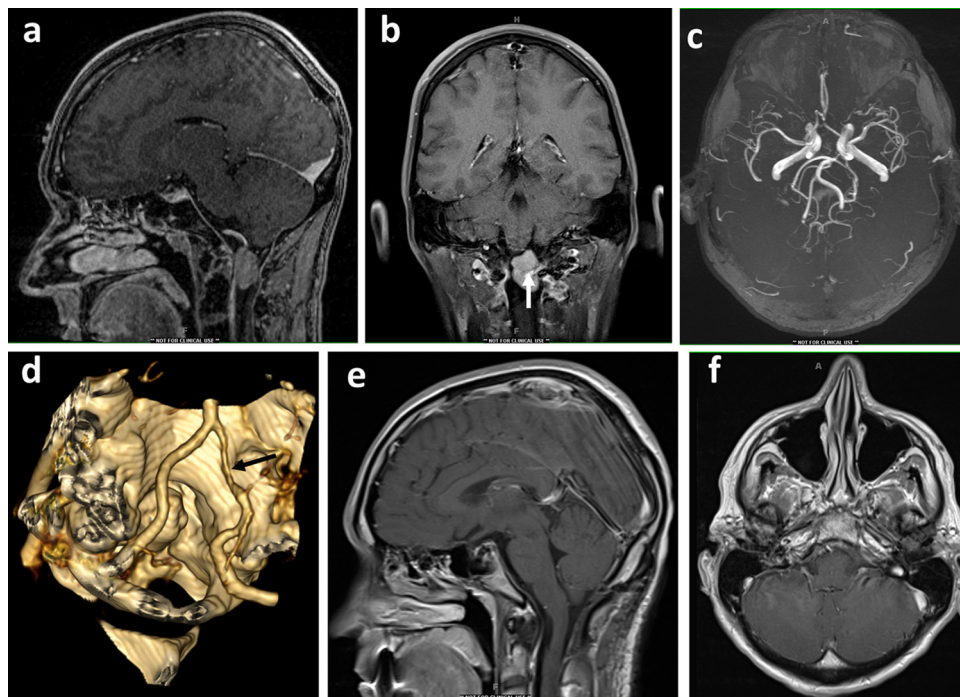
This 36-year-old male patient presented with numbness in both hands, headache and gait instability. MRI scans (a–b) revealed an anterolateral spinocranial meningioma ($3 \text{ cm} \times 1.9 \text{ cm} \times 1.6 \text{ cm}$) encasing the vertebral artery (arrow). Pre-operative CT angiogram (c) and intra-operative MRA (d) shows the narrowing of the branch of the VA encased by the tumor. He underwent a suboccipital craniectomy and C1 laminectomy with left lateral approach to the C1 and foramen magnum area with an exposure of the vertebral arteries. Post-operatively, he recovered well except developing some atrophy of the infraspinatus and supraspinatus muscle and possibly a part of the deltoid. MRI (e and f) at follow-up showed complete resection of the tumor.
